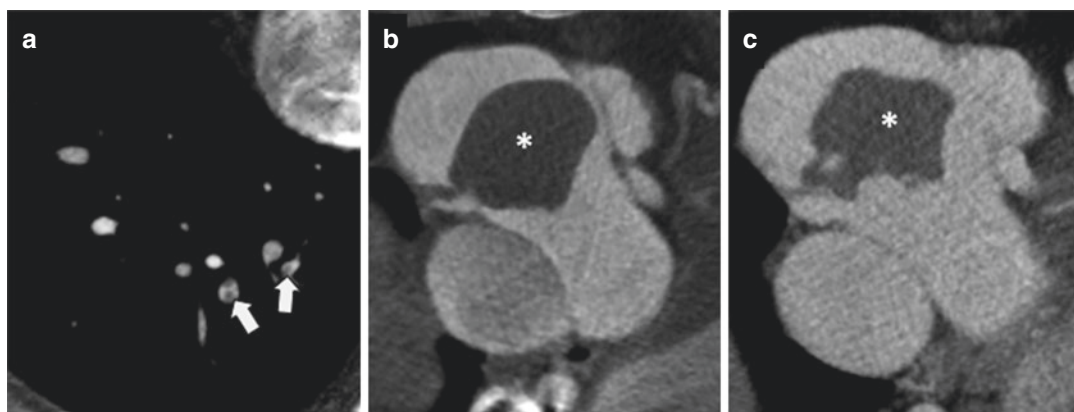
Cardiac CT to identify thrombus in a Fontan patient. (a) The patient presented with acute breathlessness, and CT pulmonary angiogram demonstrated right lower lobe filling defects (arrows) consistent with pulmonary emboli. (b) Axial CT image with large low attenuation mass (asterisk) in the right atrium, consistent with thrombus and attached by a thin stalk to the posterior
